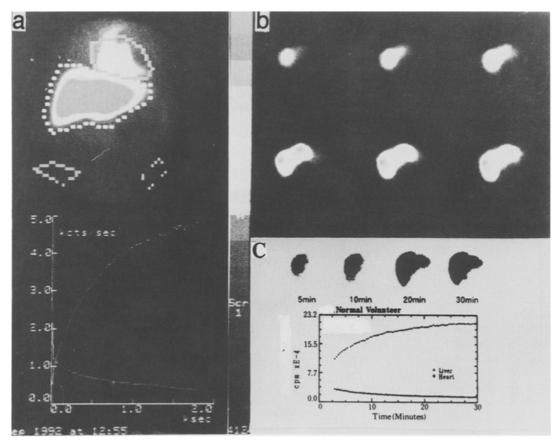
Time-activity data from the ^{99m}Tc-GSA study. (a) ^{99m}Tc-GSA dynamic image and time-activity curve obtained for a normal volunteer after intravenous injection of a 3-mg dose of ^{99m}Tc-GSA. (b) At 30 min after injection, a SPECT image of the liver was obtained. (c) Receptor concentration (HBP) obtained by pharmacokinetic modeling is 0.714 in normal volunteer
